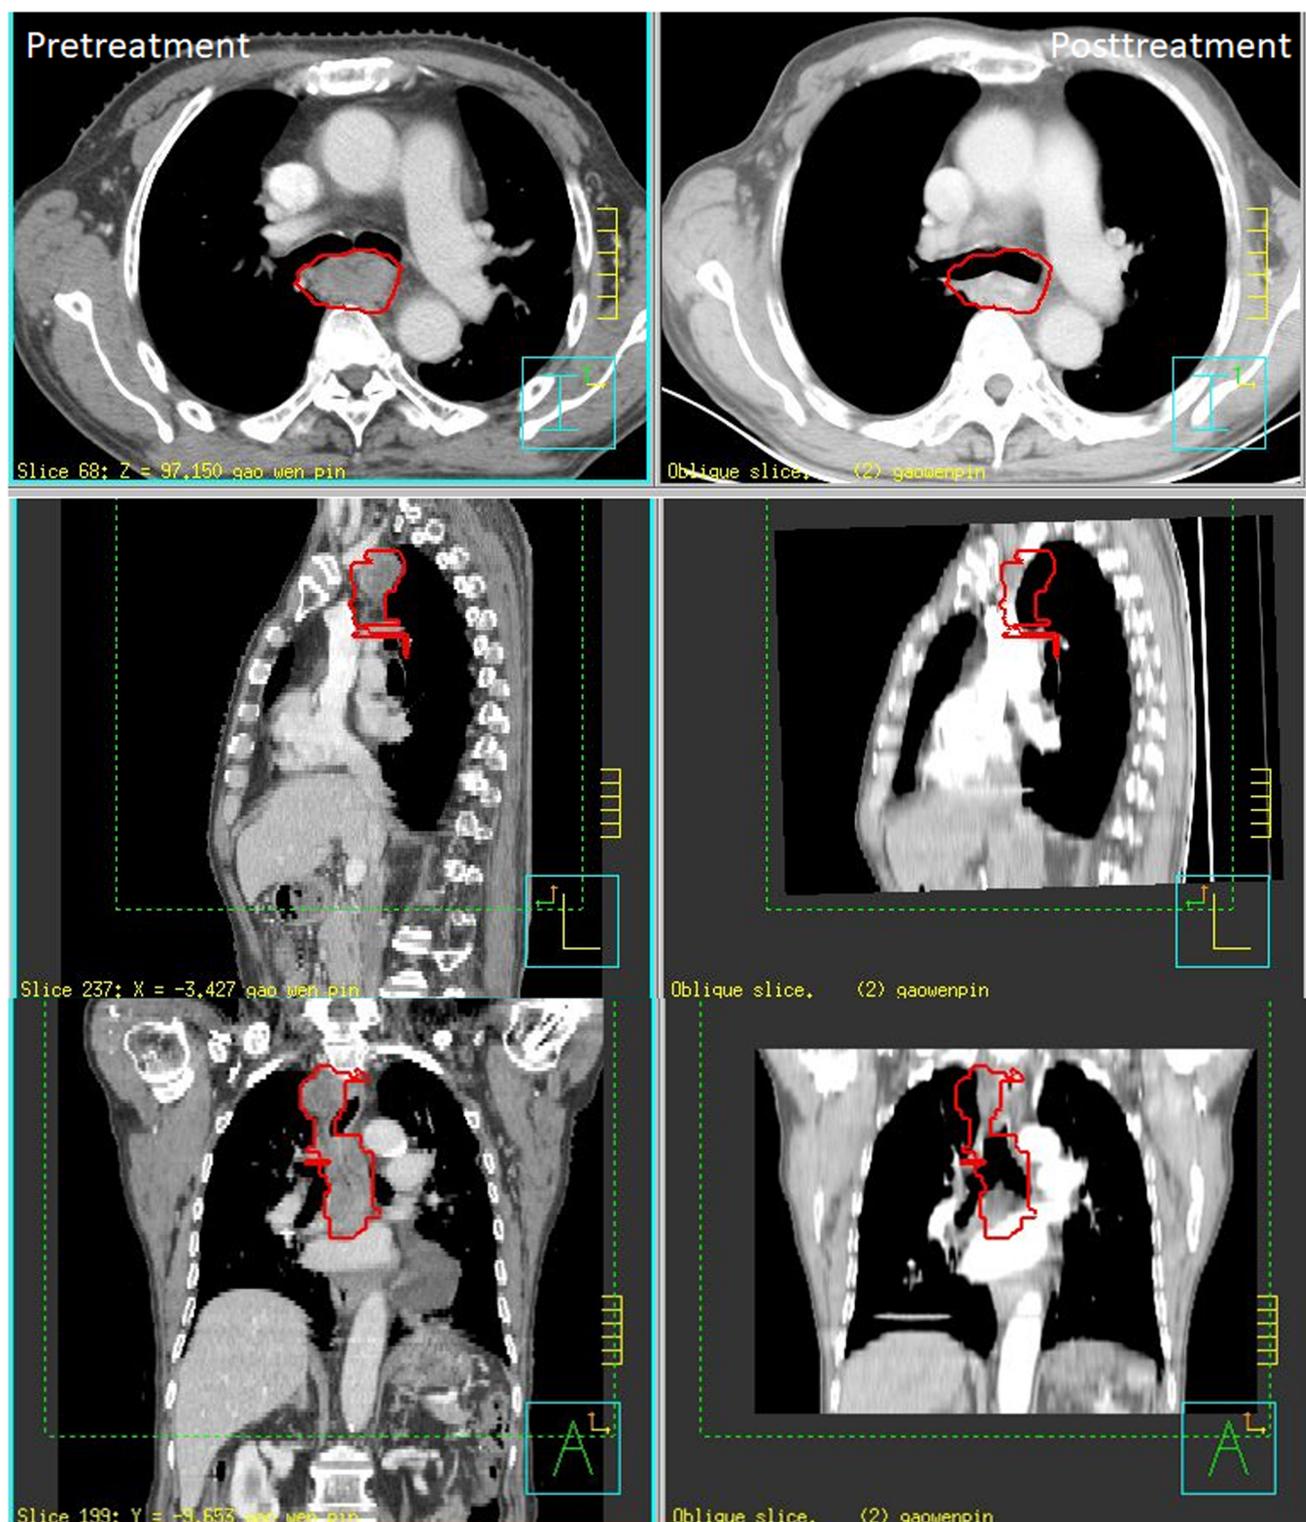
Typical pretreatment and posttreatment CT images for treatment response evaluation
